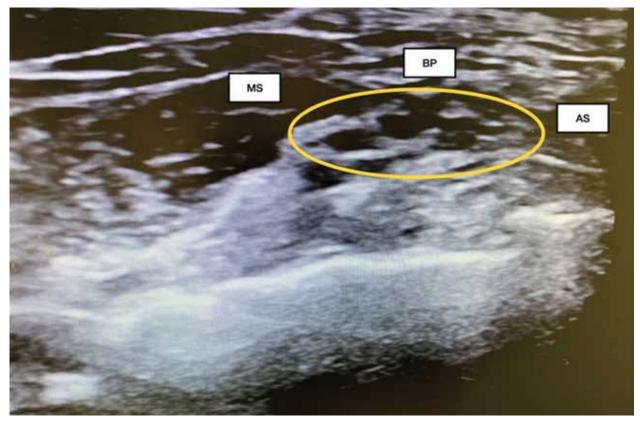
Sonographic view of the middle scalene muscle (MS), anterior scalene muscle (AS), and brachial plexus (BP).
